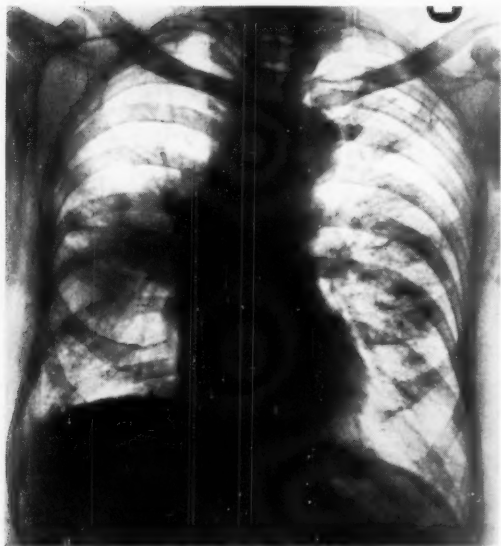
POSTERO-ANTERIOR RADIOGRAPH (8.3.51) SHOWING EXTENSIVE SHADOWING IN THE RIGHT MIDDLE ZONE AND A SMALL AREA OF SHADOWING IN THE LEFT MIDDLE ZONE.
